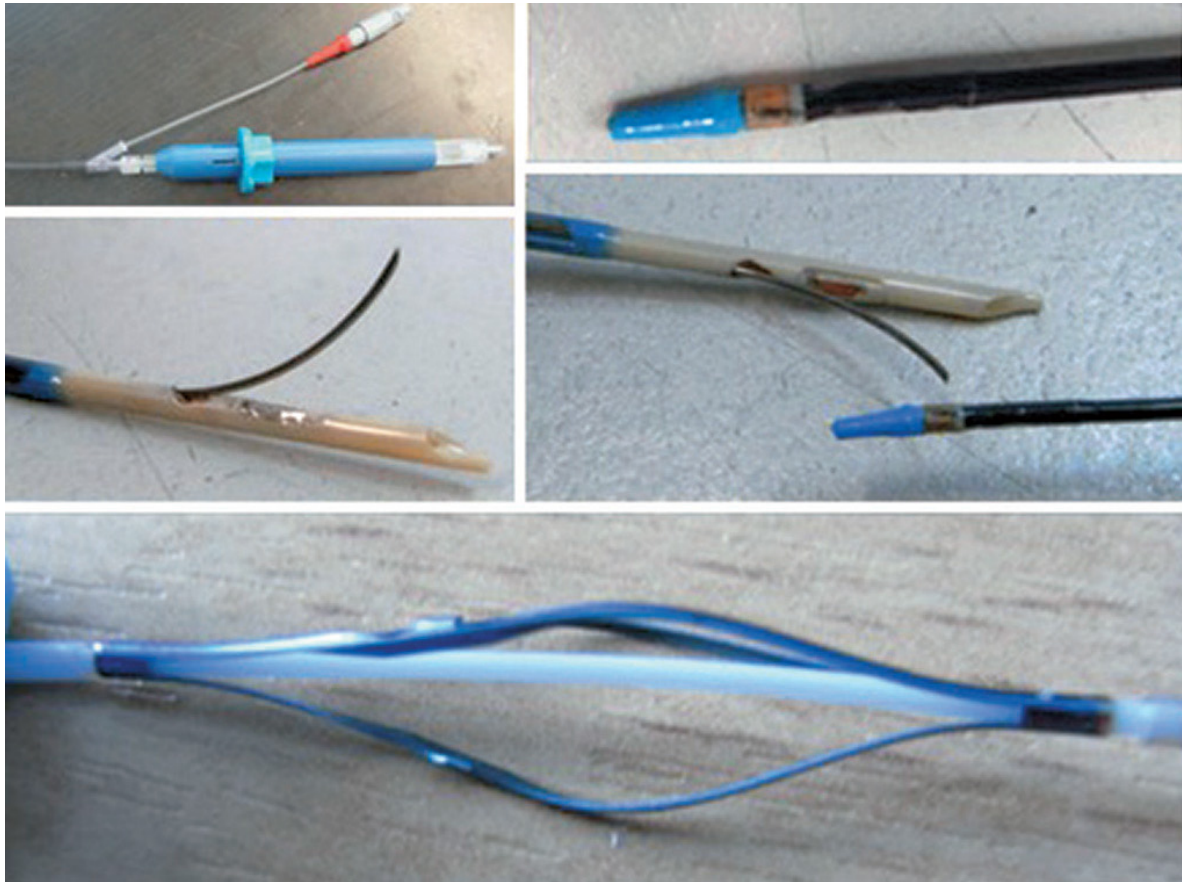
Arterial ultrasound catheter with needle
